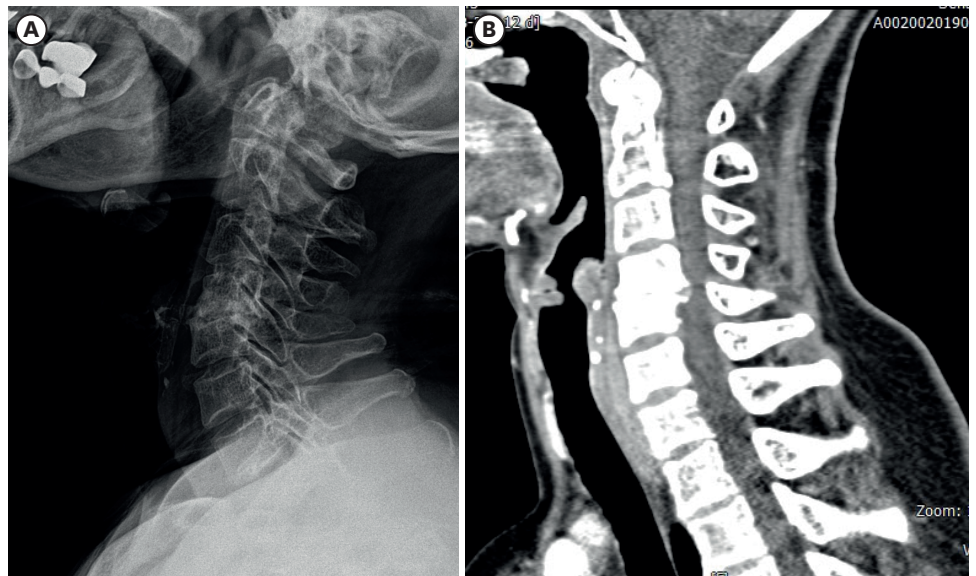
Cervical spine view is showing that the body of C4 had retrolisthesis in relation to C5, severe narrowing of the intervertebral disc space, and sclerotic changes with a posterior bony spur on the endplate of C4. (A) X-ray and (B) computed tomography. C4: cervical vertebra 4, C5: cervical vertebra 5.
